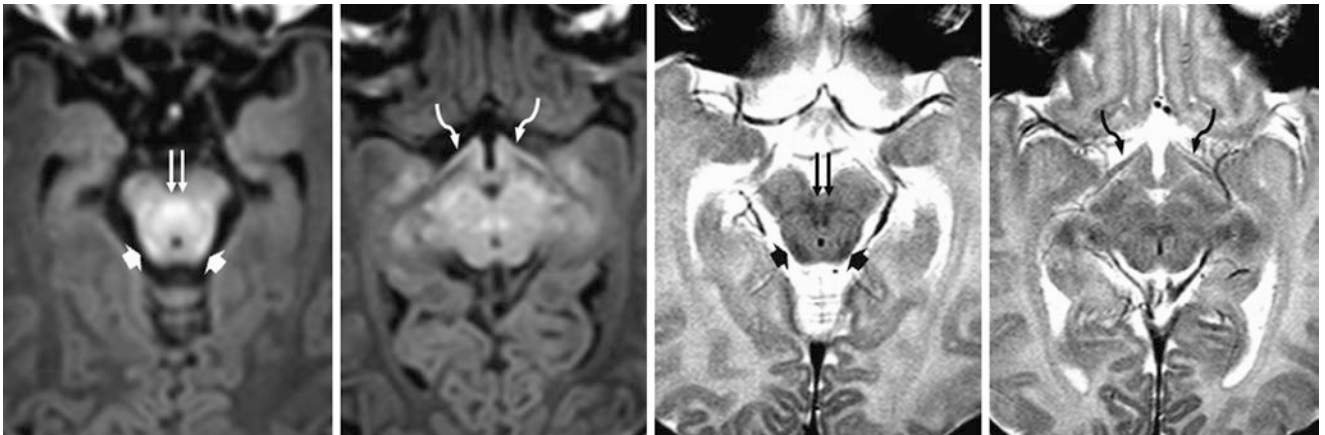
A 4-day-old term neonate had a normal 3T MRI with GE T1WIs (*left images*) and SE T2WIs (*right images*). The BIC/inferior colliculi (*wide arrows*), DSCP (*double arrows*), and optic tracts (*curved arrows*) appear myelinated, being bright on T1WI and dark on T2WI
